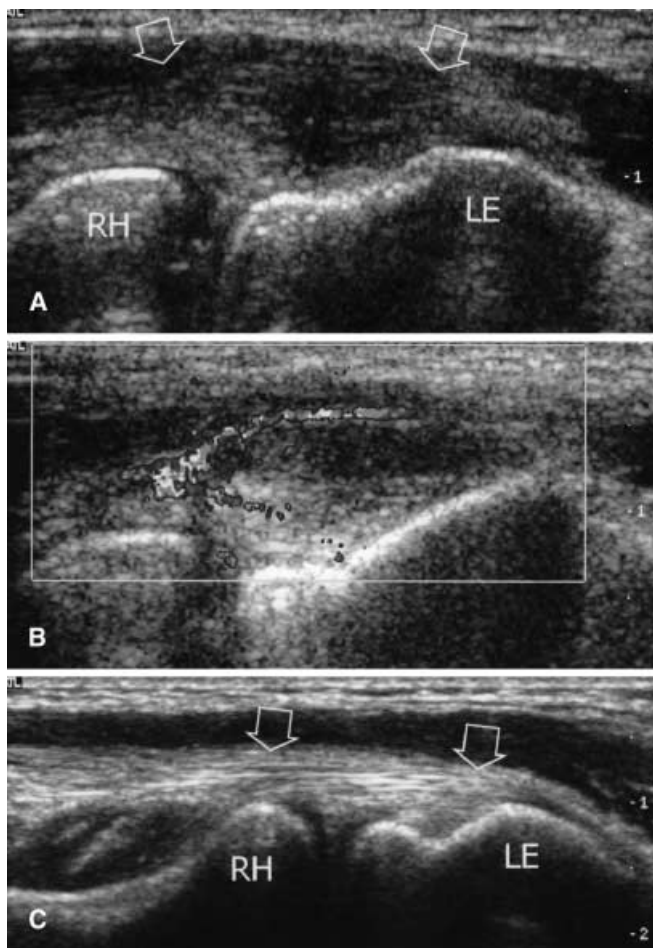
Lateral epicondylitis. A Longitudinal 5–12 MHz US image at the lateral elbow in a tennis player with chronic elbow pain reveals a swollen common extensor tendon (*arrows*) with a full-thickness hypoechoic area compatible with tendinosis. *LE* lateral epicondyle; *RH* radial head. B The tendon appears hypervascular at color Doppler imaging. C Normal contralateral US scan
